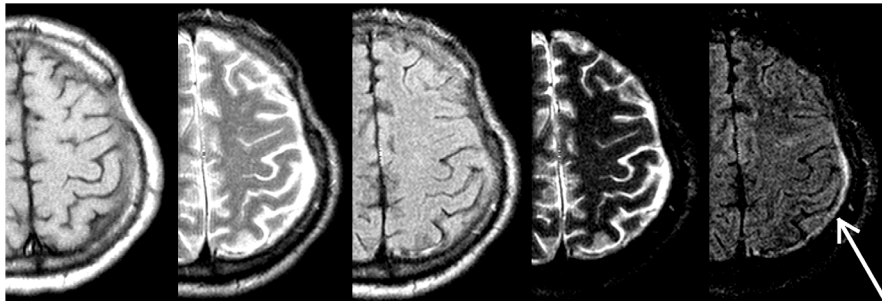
MRI data for the same FOV for the patient after surgery of subdural haematoma. From left to right: T1WI, T2WI, FLAIR, STIR-T2WI, double inversion recovery. Pathological changes are indicated by arrow.
